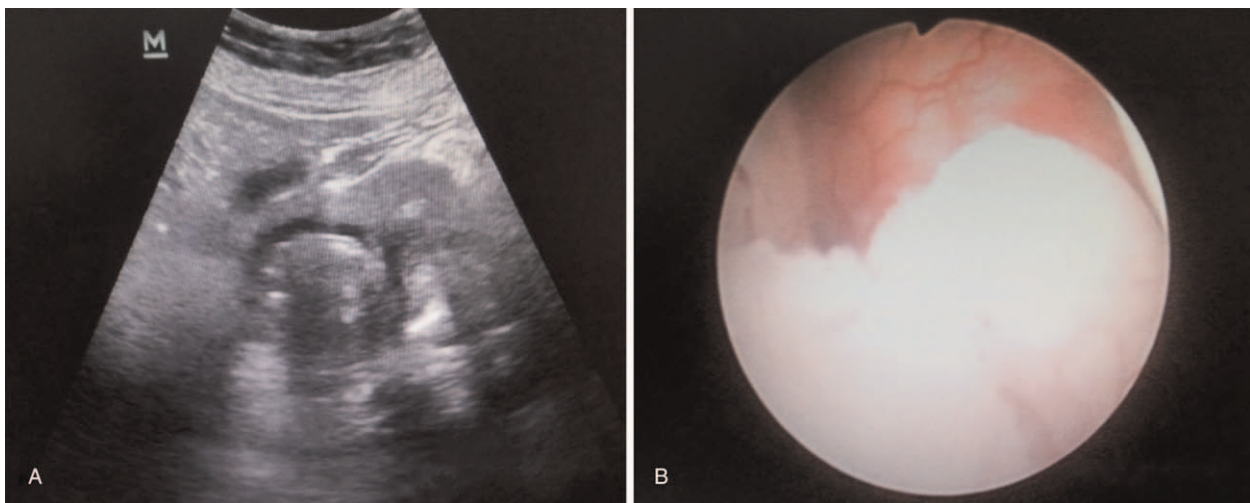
Color ultrasonic examination (A) shows an endometrial mass of 33*38*31 mm in dimension. Hysteroscopy (B) shows the posterior wall of uterus endometrium was significantly thickened and the surface had atypical blood vessels.
